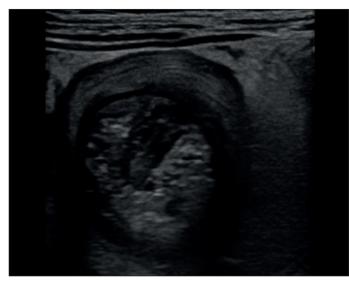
Target sign in ultrasonography imaging
